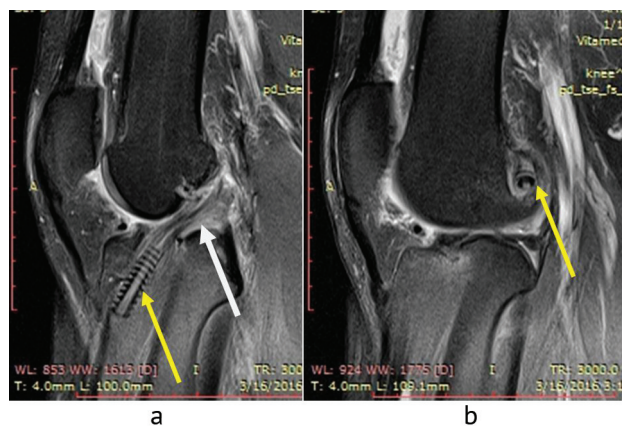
Postoperative sagittal MRI views of the knee showing biodegradable screws in tibial tunnel (yellow arrow) and autograft (white arrow)
